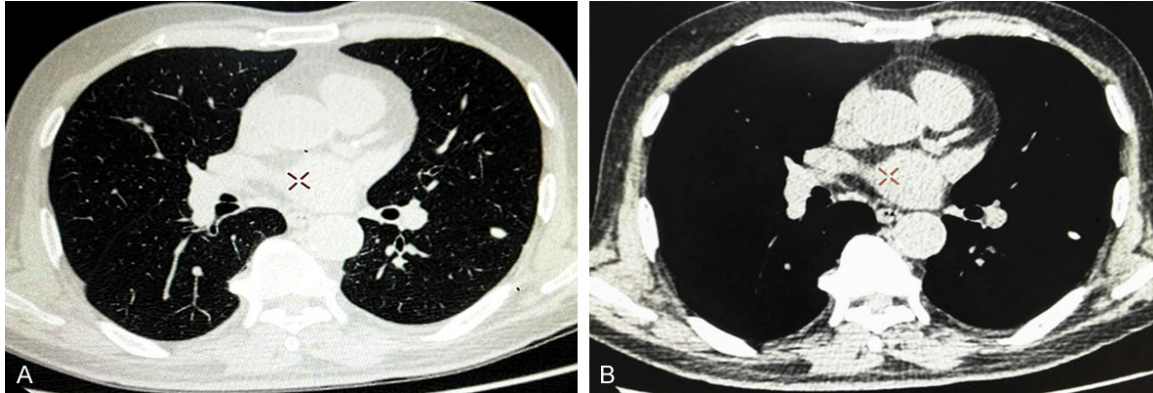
CT findings of pulmonary metastasis. Chest CT revealed nodular shadows in both lungs (A: Lung window image; B: Mediastinal window image).
